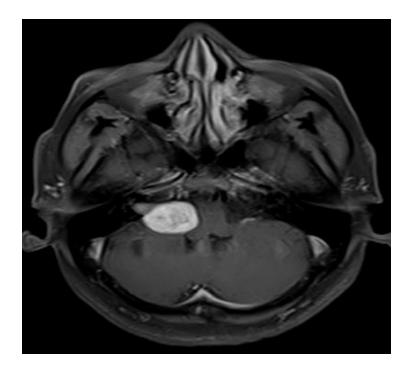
Vestibular schwannoma. Complementary contrast enhanced MRI image in the same patient shows a heterogeneous avidly enhancing extra-axial lesion at the right CP angle with few cystic components within (thin arrow). Intra-canalicular segment and trumpeted IAC is well seen (block arrow). These findings were suggestive of vestibular schwannoma.
